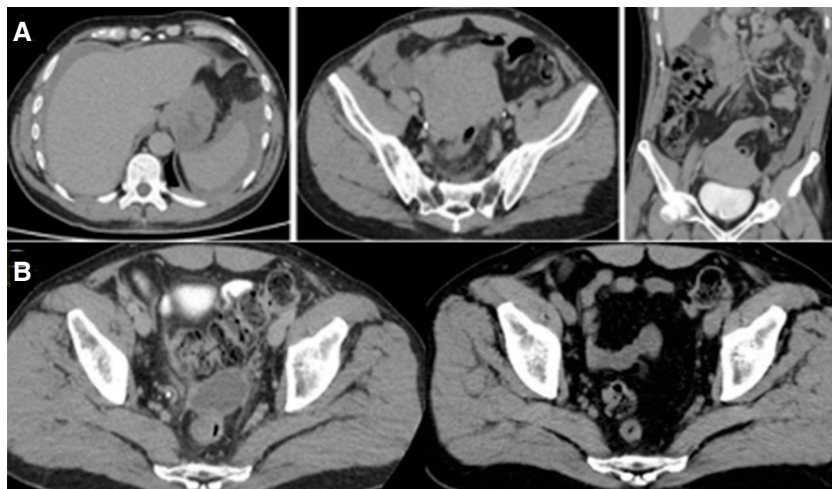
Image A, CT scan showing free intraperitoneal fluid with intermediate density in perihepatic, perisplenic regions, interloop spaces, and along the paracolic gutter. Hematic collection on top of the bladder and in straight relation to prostate gland of 104× 86 mm (intraperitoneal). Image B, Left side image: CT scan showing 71 mm hematic collection surrounding prostate gland. Right side image: CT showing no collection after 5 months
